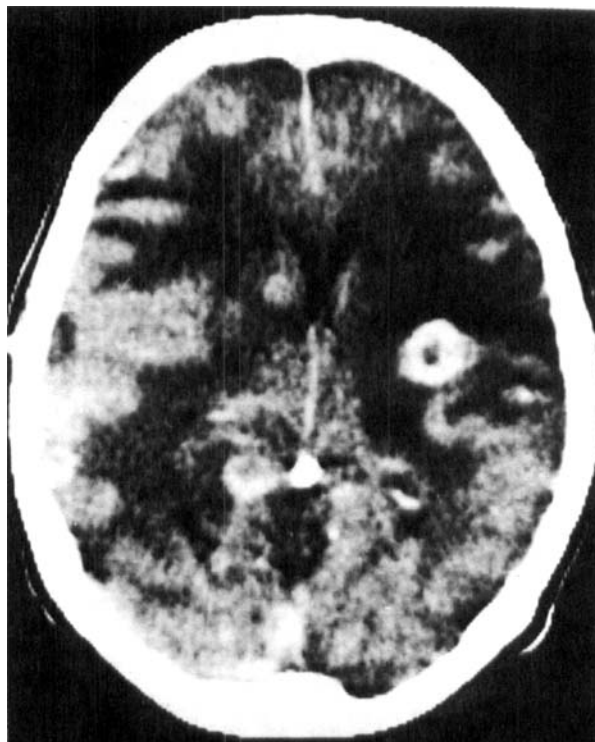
CT of head showing bilateral edematous changes with compression of the lateral ventricles. There are at least three areas of contrast enhancement appearing as metastases. The largest one is about 2 cm in diameter.
